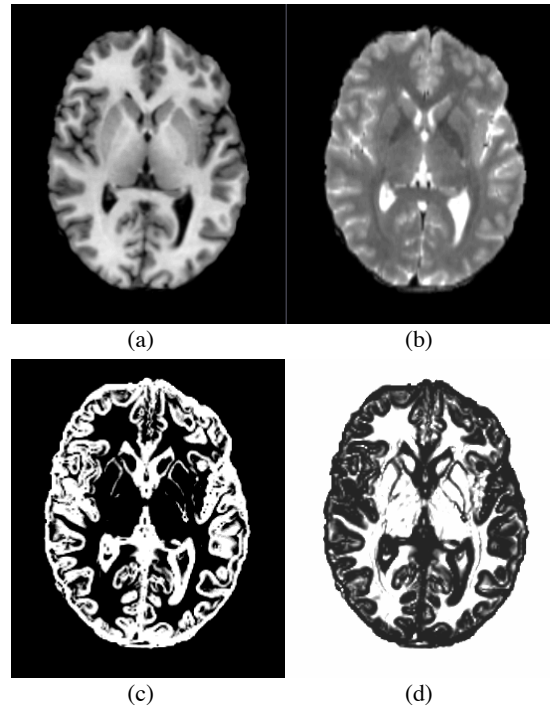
Created spatial weights based on the anatomical edges estimated from the high-resolution structural MR modalities. (a) T1-weighted MR image. (b) T2-weighted MR image. (c) Estimated edge map based on the maximum gradient values as described in section 4.3.2. (d) Prior spatial weights created from estimated edge map based on equation (4.36).
